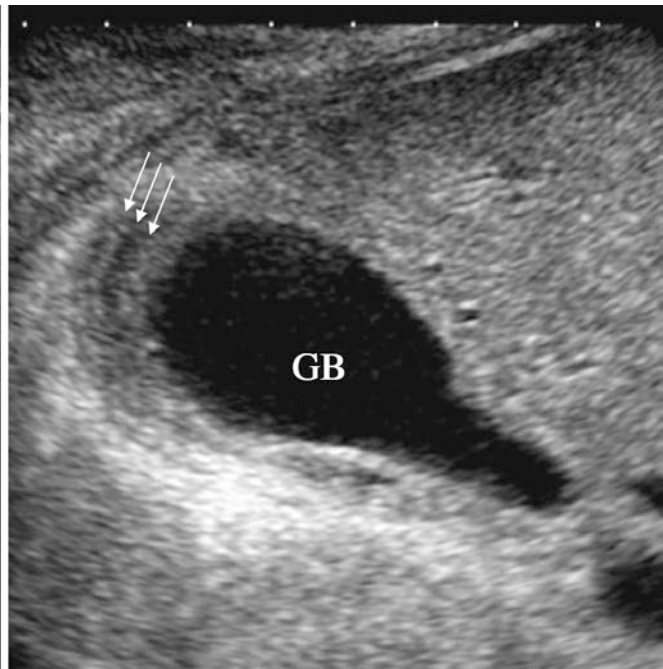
Thickened gallbladder wall on ultrasound. (From Kimura Y et al. TG13 current terminology, etiology, and epidemiology of acute cholangitis and cholecystitis. J Hepatobiliary Pancreat Sci. 2013;20:12.
